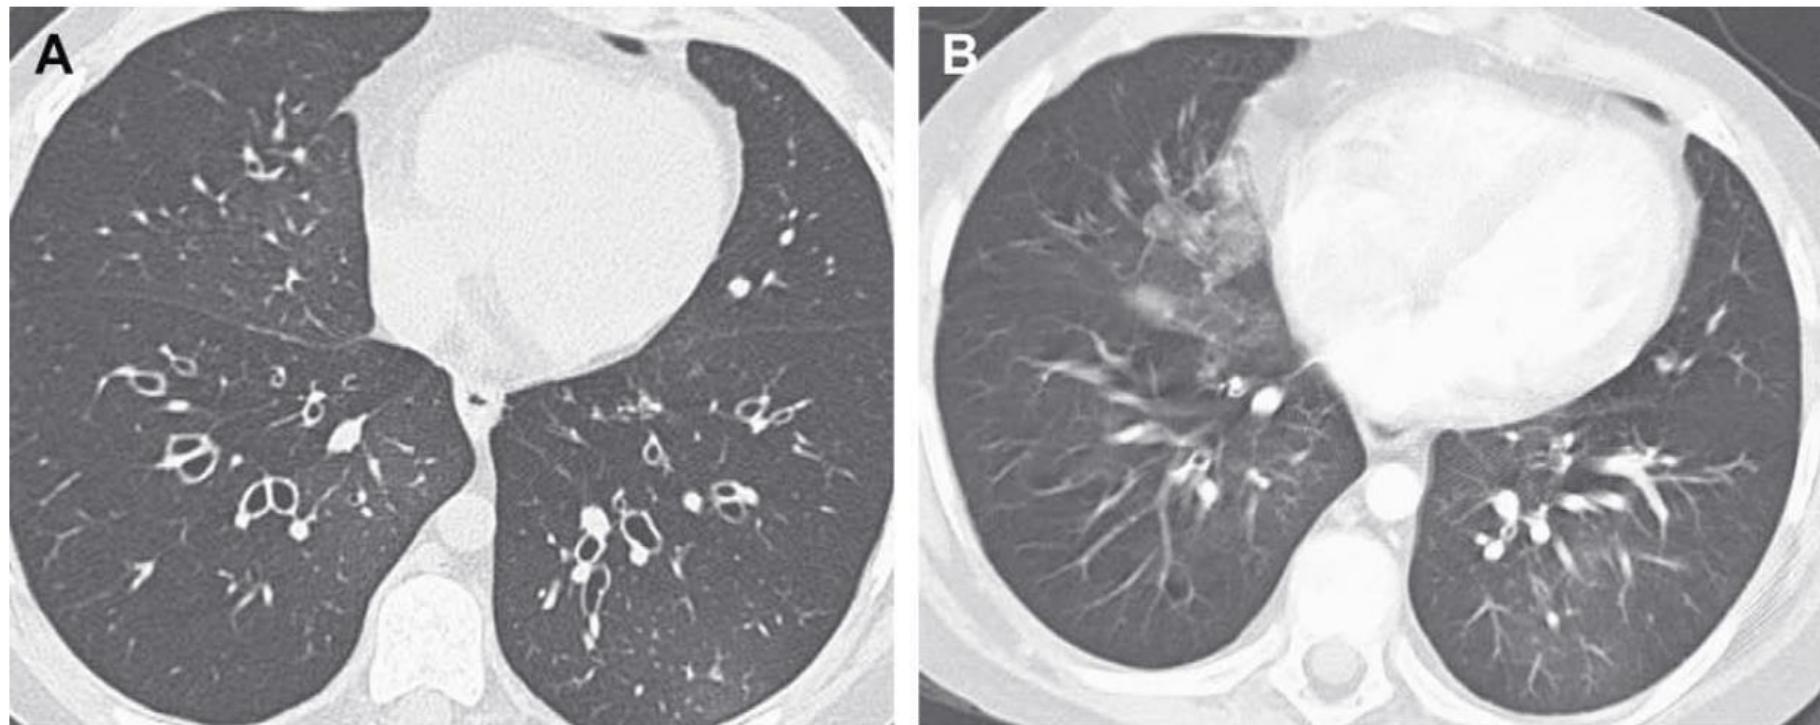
Reversible lower lobe bronchial dilatation due to pneumonia. Initial CT (*A*) in this 12-year-old girl with hypogammaglobulinemia and pneumonia showed bilateral dilated lower lobe bronchi. Subsequent CT (*B*) performed 6 months later showed resolution of the bronchial dilatation, although it revealed a right middle lobe pneumonia. Because this dilatation is reversible, it would not qualify as bronchiectasis.
